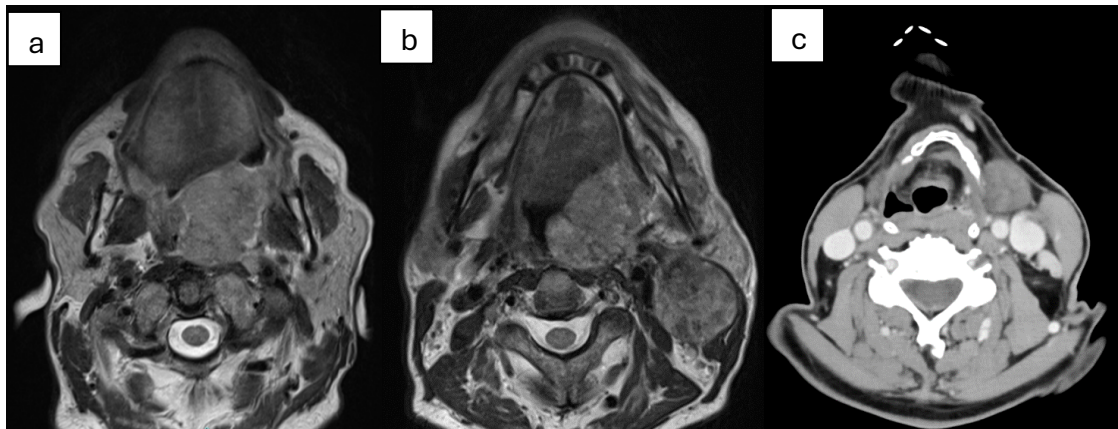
MRI and CT axial sections before chemotherapy. A) MR image with axial cut in the lingual plane; b) MRI image with axial cut in the mandibular plane; c) CT image with axial cut on the plane of the hyoid bone.
